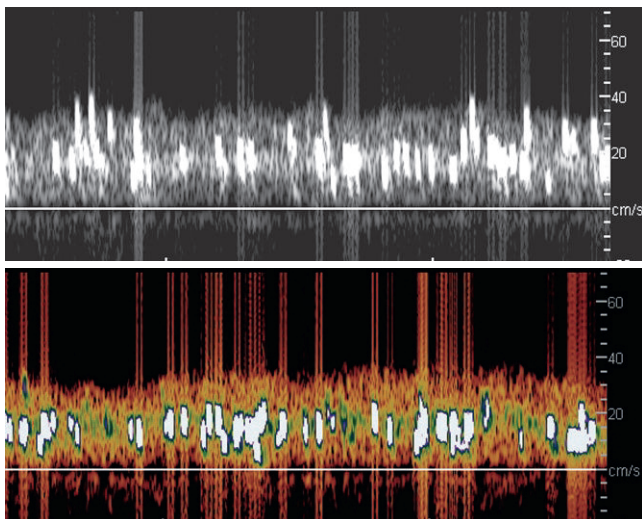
The characteristic spectral Doppler spikes from gas are seen superimposed on the normal portal blood flow. Additionally dense white echoes in the spectrum indicate gas that has not produced a spike. The image on the bottom represents a colorized spectrum that some laboratories use to make some gray scale findings more conspicuous.
